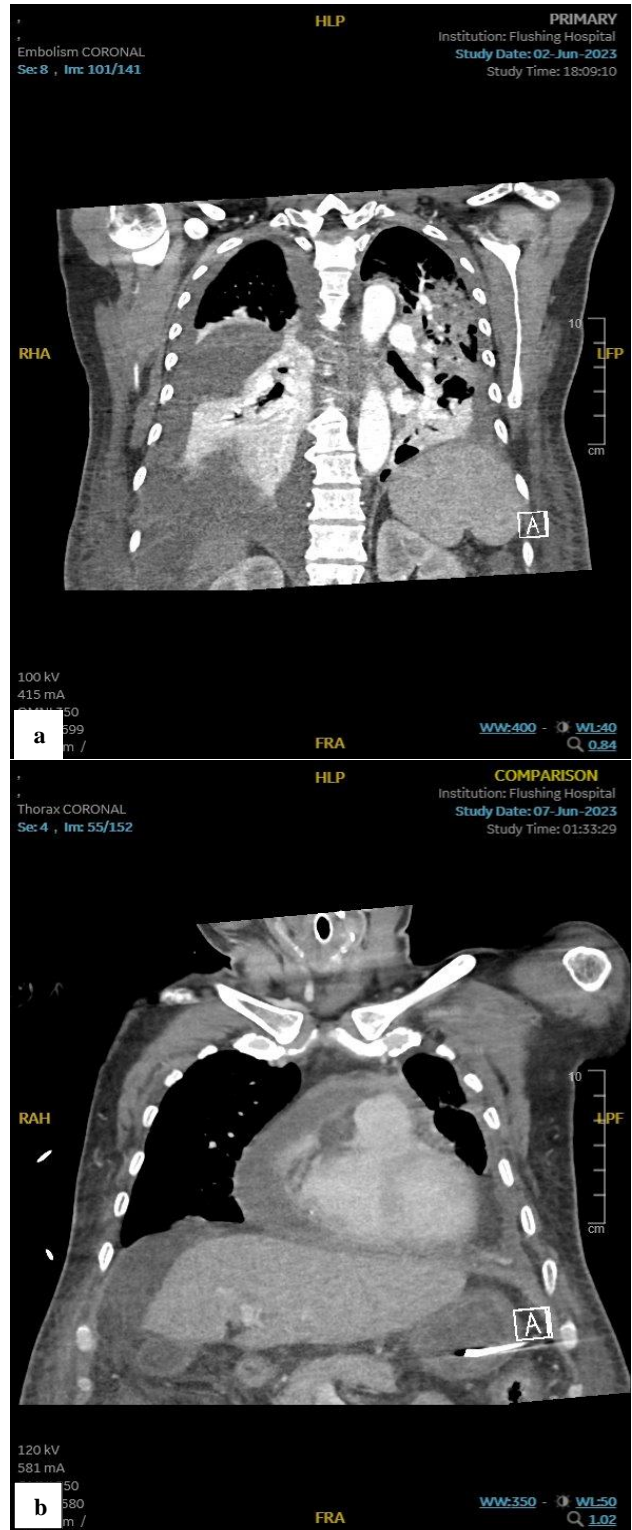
(a & b): CT chest post attempted pericardial drain placement.
